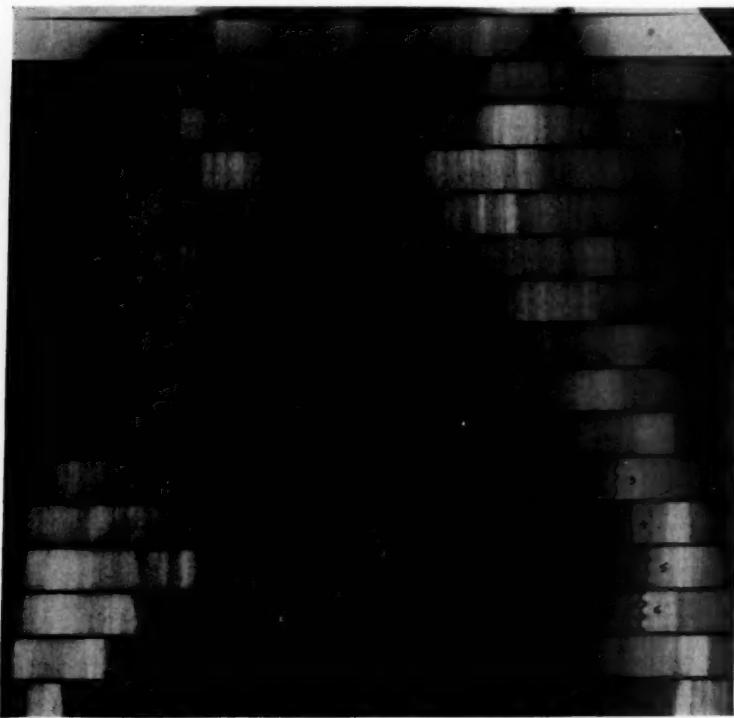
Posteroanterior roentgenkymogram from a man 53 years old. Coronary artery occlusion one week previously. Localized diminution in pulsation is seen in interval four of the left ventricular contour, and systolic expansion in intervals five and six.
